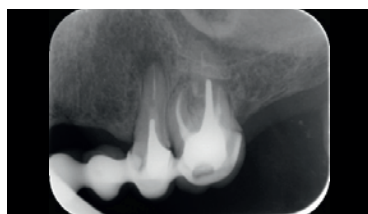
6 months control periapical radiograph after upper left first molar root canal retreatment.
